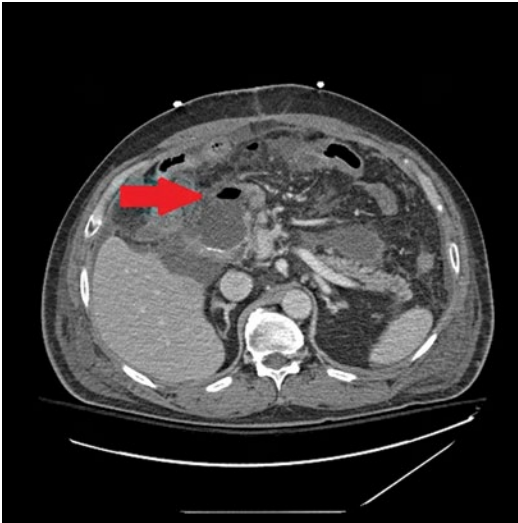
Computed tomography (CT) image of a patient with duodenal stump leakage after subtotal gastrectomy. Red arrow indicates fluid and air at duodenal stump staple line
